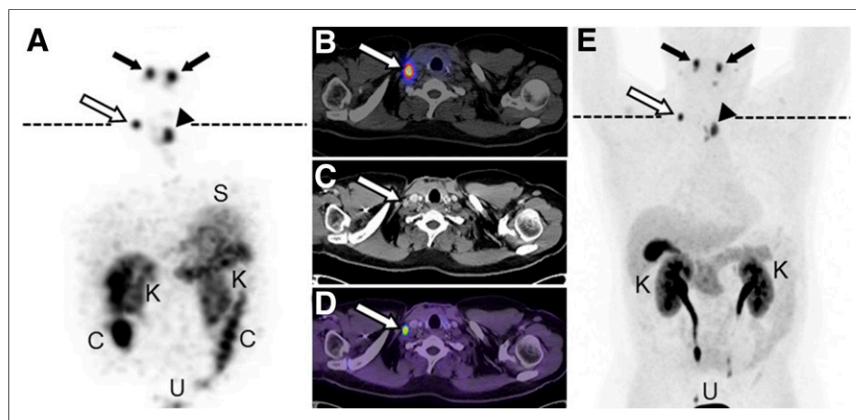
Patient with metastatic MTC, whole-body SPECT (A) and transaxial SPECT/CT (B) images 24 h after injection of 1,071 MBq of ^{177}Lu -DOTA-PP-F11N; contrast medium-enhanced transaxial CT image (C); and transaxial PET/CT (D) and whole-body PET (E) images 30 min after injection of 230 MBq of ^{18}F -DOPA. Dashed lines indicate level of transaxial slices. SPECT and SPECT/CT show highly ^{177}Lu -DOTA-PP-F11N-avid recurrent disease in left thyroid bed (arrowhead), 2 retropharyngeal lymph node metastases (black arrows) and 1 right supraclavicular lymph node metastasis with diameter of 1 cm (white arrow). This finding was confirmed by CT and ^{18}F -DOPA PET/CT. Whole-body SPECT shows additional ^{177}Lu -DOTA-PP-F11N accumulation in stomach (S), kidneys (K), colon (C), and urinary bladder (U).
